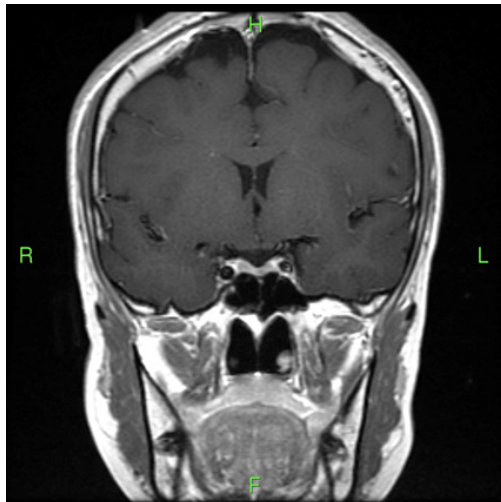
MRI pituitary without and with contrast: Significantly diminished height of the pituitary gland may be based on hypofunction or hyperstimulation. In addition, exogenous administration of hormones could result in a similar appearance.
